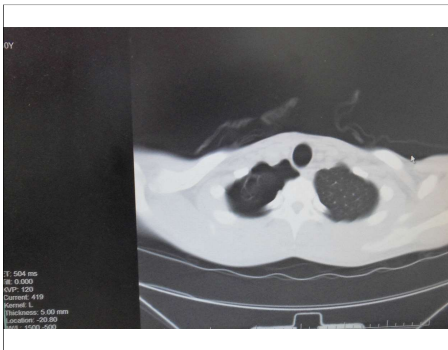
Preoperative chest CT images.
